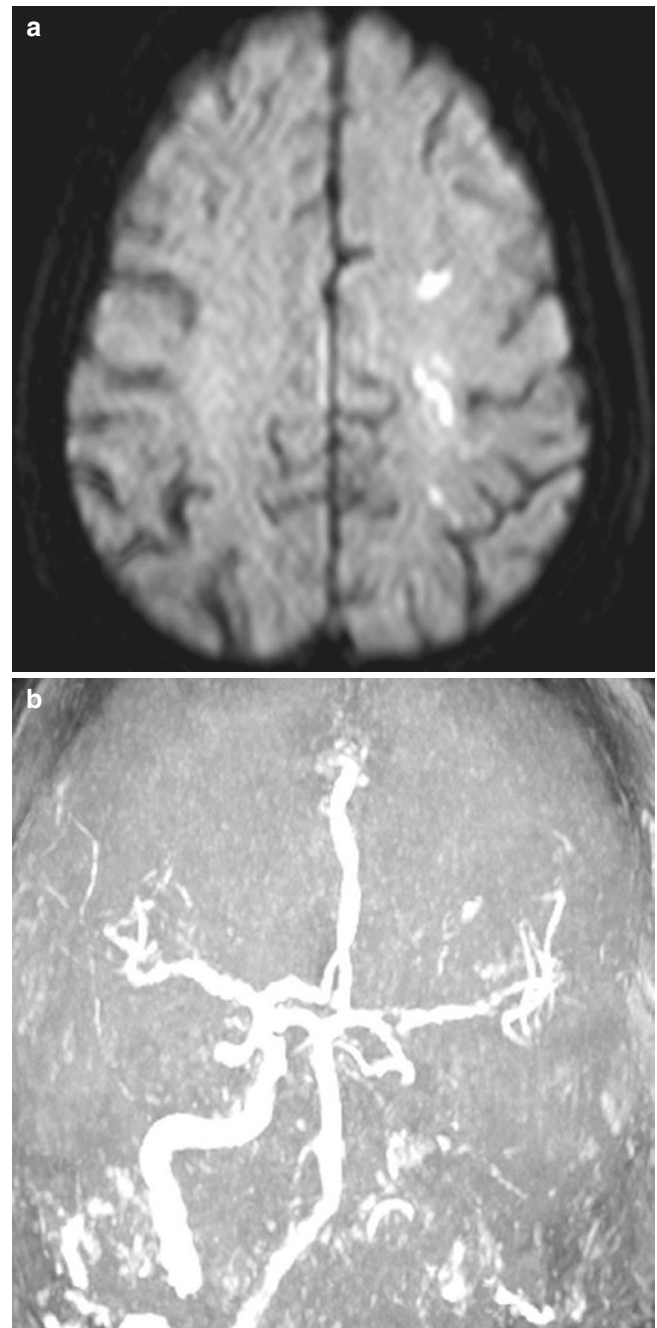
Internal subcortical border zone infarction. (a), DWI shows a string of small infarctions in the centrum semiovale in the internal border zone of lenticulostriate and deep perforating medullary artery of left MCA. (b), MRA MIP image shows occlusion of the left ICA
